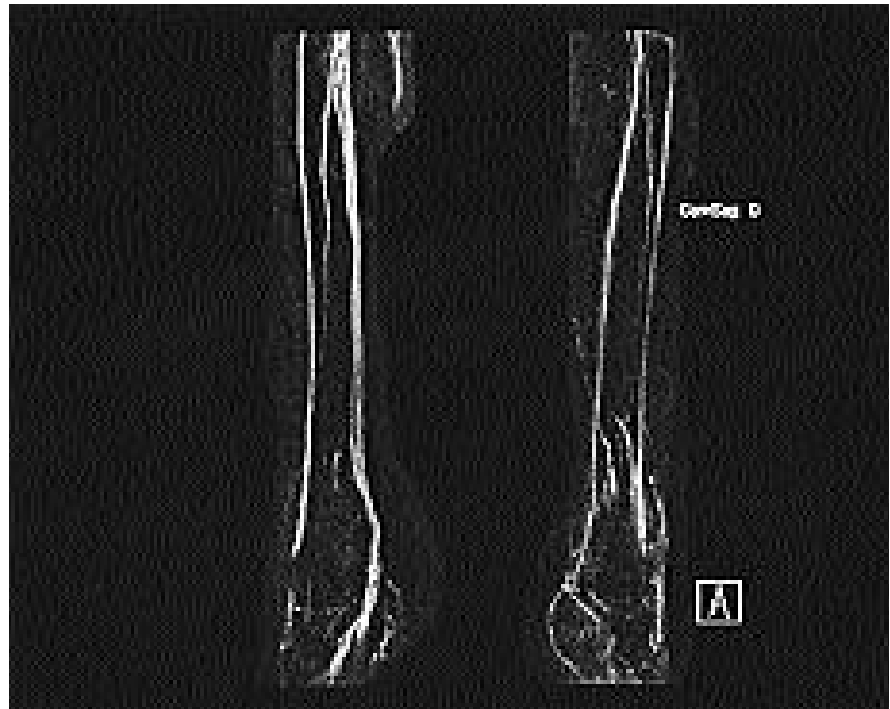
Magnetic resonance angiogram demonstrating patent vessels in the distal lower limbs. The MRI/MRA of the proximal vessels was normal (not shown).
